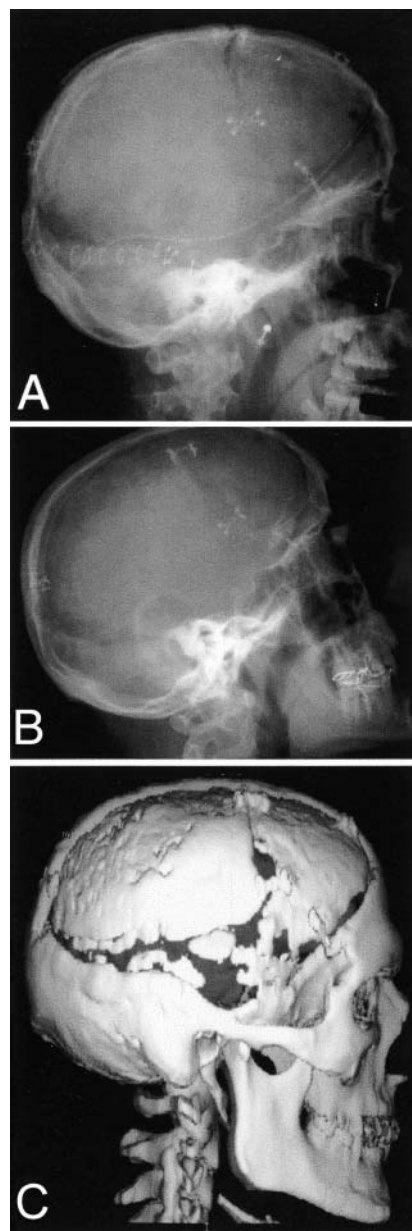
Imaging studies obtained in a 14-year-old boy. A: Radiograph obtained after autologous bone cranioplasty. B: Radiograph obtained 15 months later after development of progressive bone resorption. C: Three-dimensional CT reconstructions acquired 2 years later.
